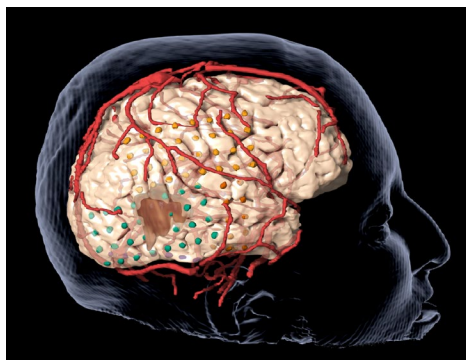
Reconstruction of pre-op MRI co-registered with post-op CT scan showing intracranial subdural grid electrodes (green and orange dots) over the right side of brain. Prominent venous structures are also overlaid.
